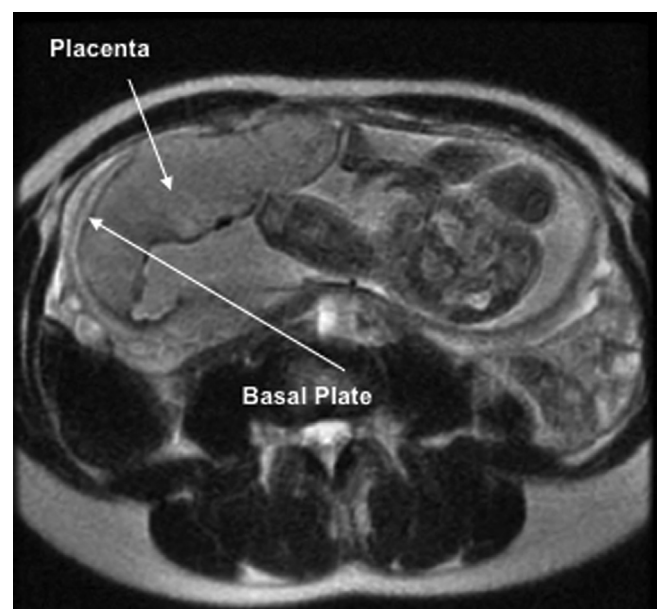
T_2 -weighted magnetic resonance image demonstrating the placental anatomy and basal plate.
